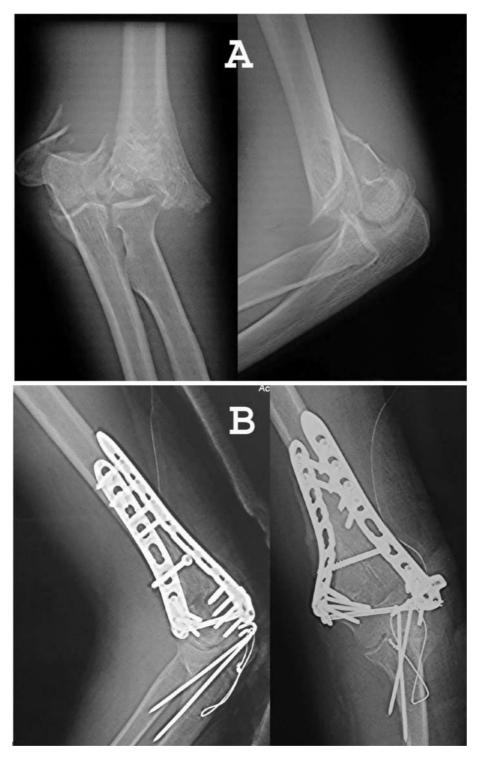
A-Case 3- Pre-operative Xray showing intercondylar fracture humerus. B-Case 3- Olecranon osteotomy post-operative Xray after fracture fixation.
